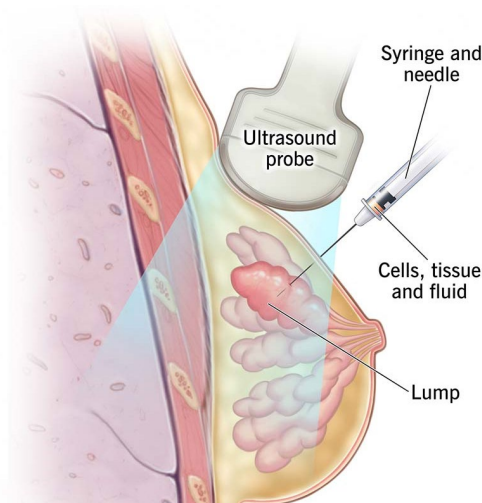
Fine needle aspiration under ultrasound guidance (adapted by Cleveland Clinic)
